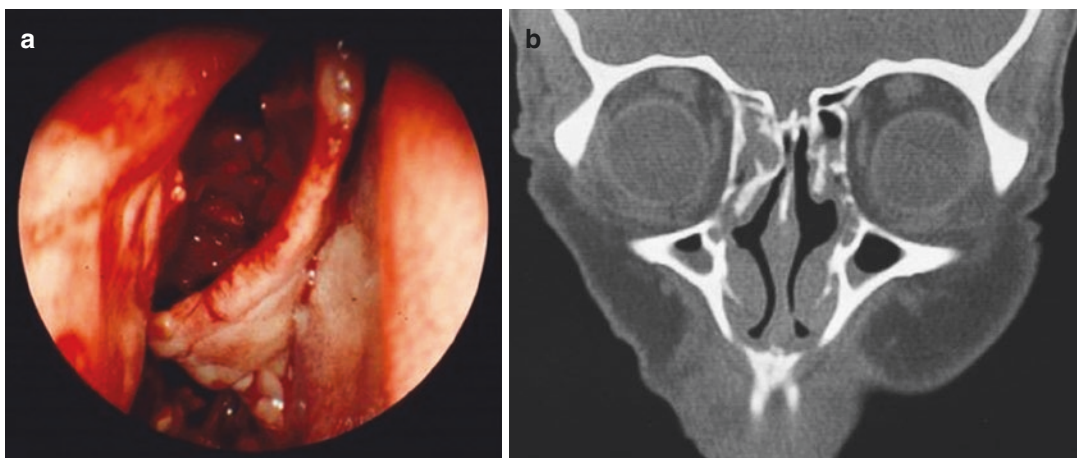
(a) Intraoperative floppy turbinate. (b) CT scan shows the lateralization of the middle turbinate. (Courtesy of Hosemann et al.: Danger points, complications, and medicolegal aspects in endoscopic sinus surgery [5])
